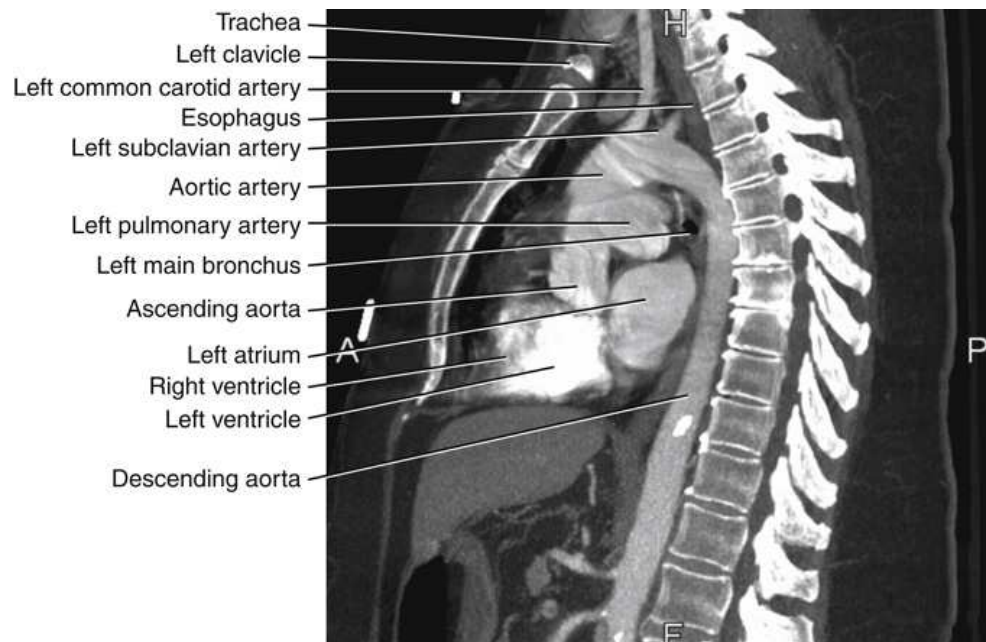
Sagittal CT image of thorax corresponding to level *B* in Fig. 24.39.
